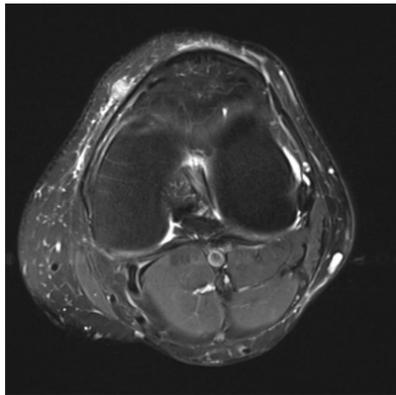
Typical MRI presentation very similar to our case [24].
